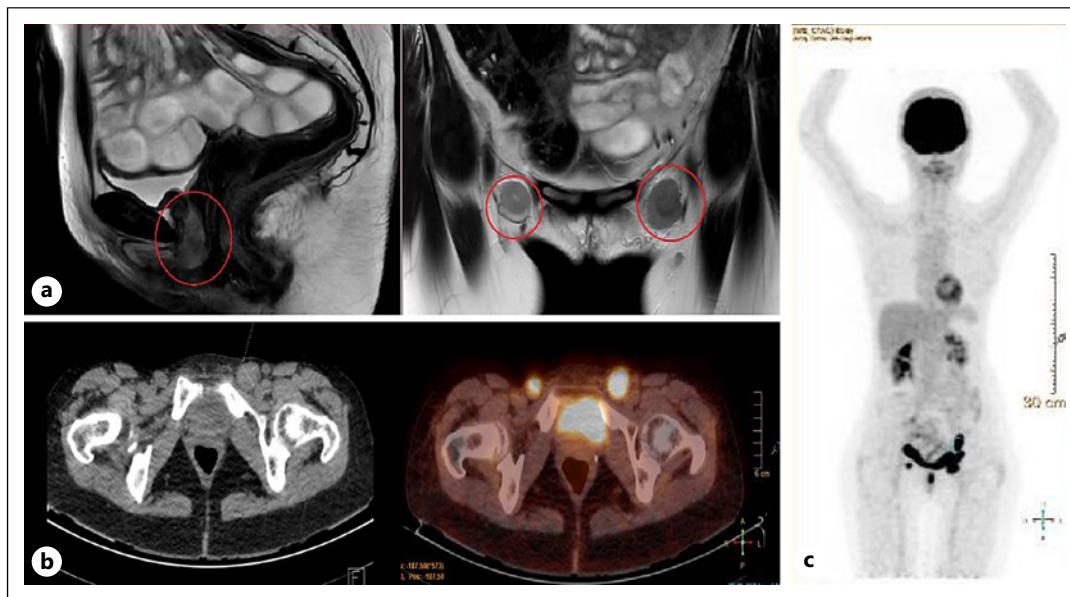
a A 48-year-old woman presenting with advanced PUC ($18 \times 21 \times 36$ mm) and bilateral inguinal adenopathies on pelvic MR (sagittal and coronal; T2 sequence). b, c 18F-FDG PET/CT demonstrated significant hypermetabolism of those two inguinal adenopathies. The left adenopathy predominated in size with 21 mm of short axis.
